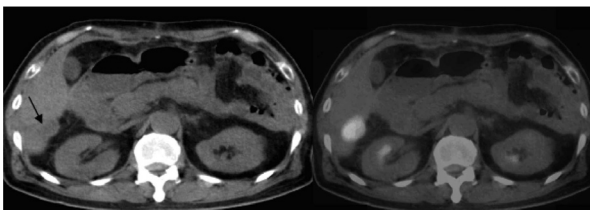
(B). The 2nd time liver metastasis. Left, abdominal CT showed S6 metastasis (arrow), which was compatible with the right-side lesion on PET/CT.
